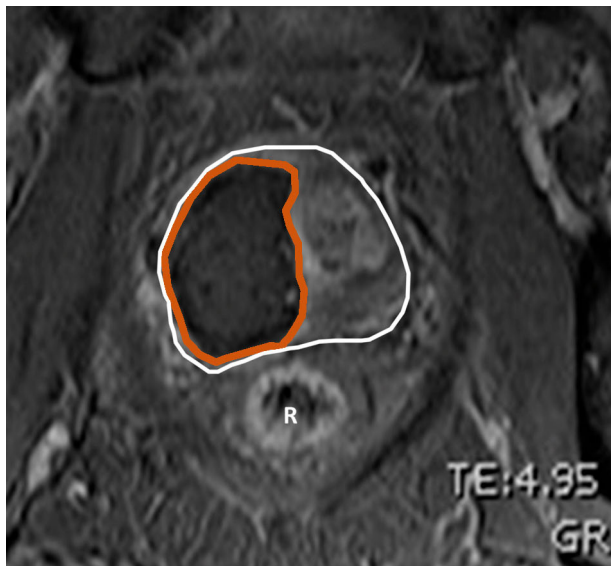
Contrast-enhanced axial scan of the prostate at mid-gland at 1 wk after high-intensity focused ultrasound ablation of an index lesion in the right prostate lobe. Example of right-sided index lesion treatment with confluent hemiablation necrosis demonstrated on early (1-wk) multiparametric magnetic resonance imaging. The orange line indicates the area of ablation with confluent necrosis, in this case hemiablation. The white line indicates the outline of whole prostate. R = rectum.
